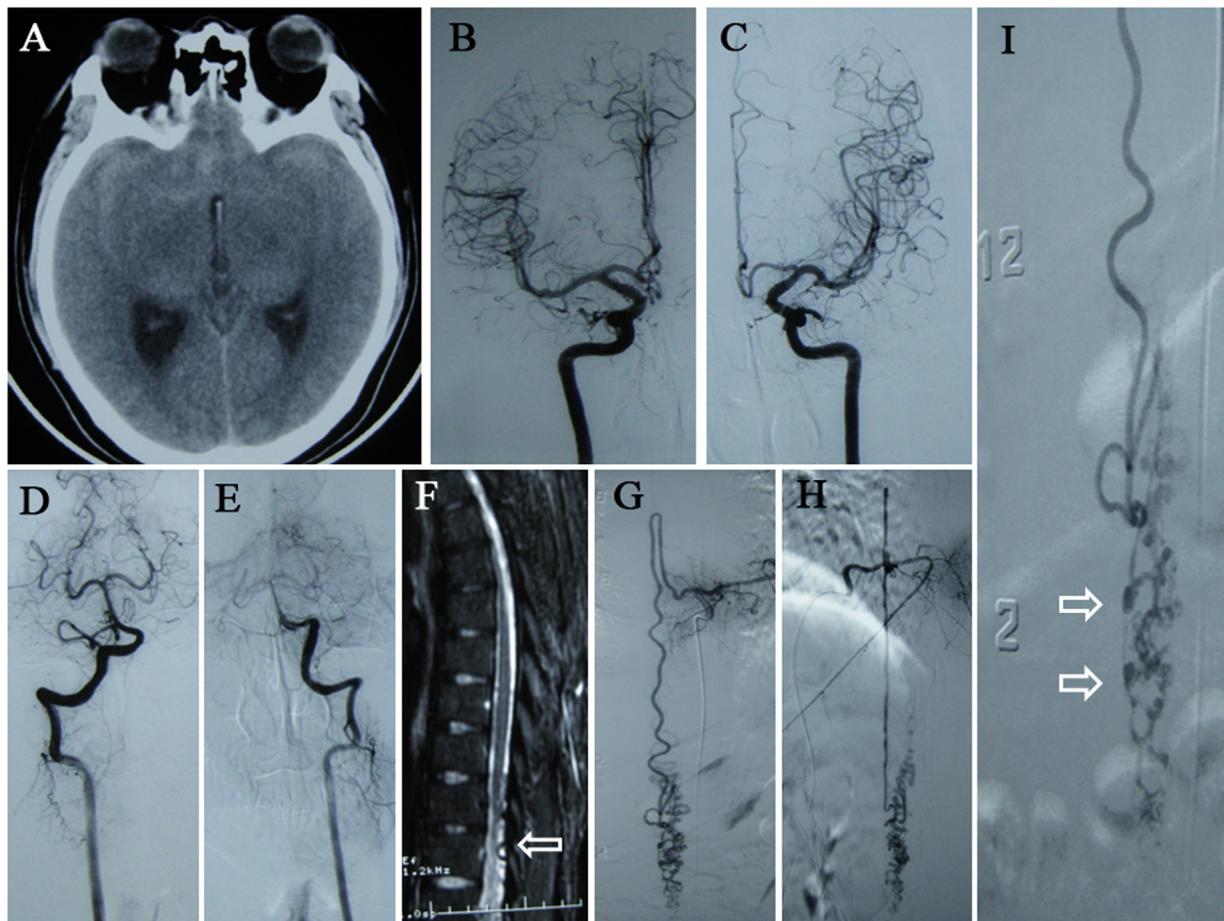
Case 1. A: On admission to the local hospital, axial CT images of the brain showed diffuse SAH in the supratentorial cistern. B-E: Cerebral DSA from the right internal carotid artery (B), left internal carotid artery (C), right vertebral artery (D) and left vertebral artery (E) were negative for aneurysms and other vascular lesions. F: T2-weighted MRI image showing perimedullary vascular flow void signal (Arrowhead) on the dorsal aspect of the T10-L1 spinal cord. G-H: Spinal DSA of the anteroposterior (G) and lateral projection (H) showed intradural ventral AVF at the L1 level fed by the anterior spinal artery from selective injection of the left T9 intercostal artery. I: Spinal DSA of the anteroposterior projection of the enlarged image shows two aneurysms on the draining vessels (Arrowhead).
